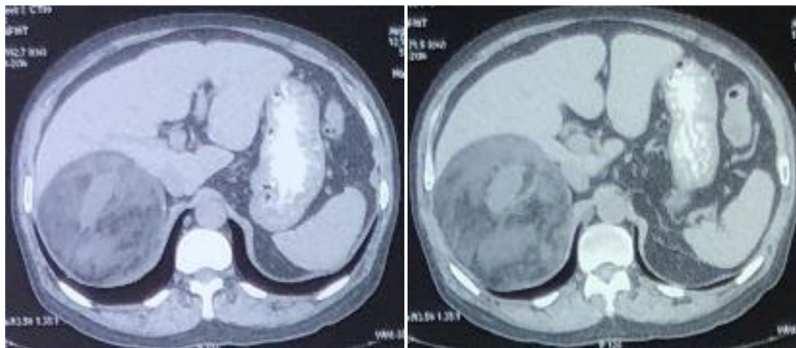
CT Scan examination showed an upper right abdomen mass.
